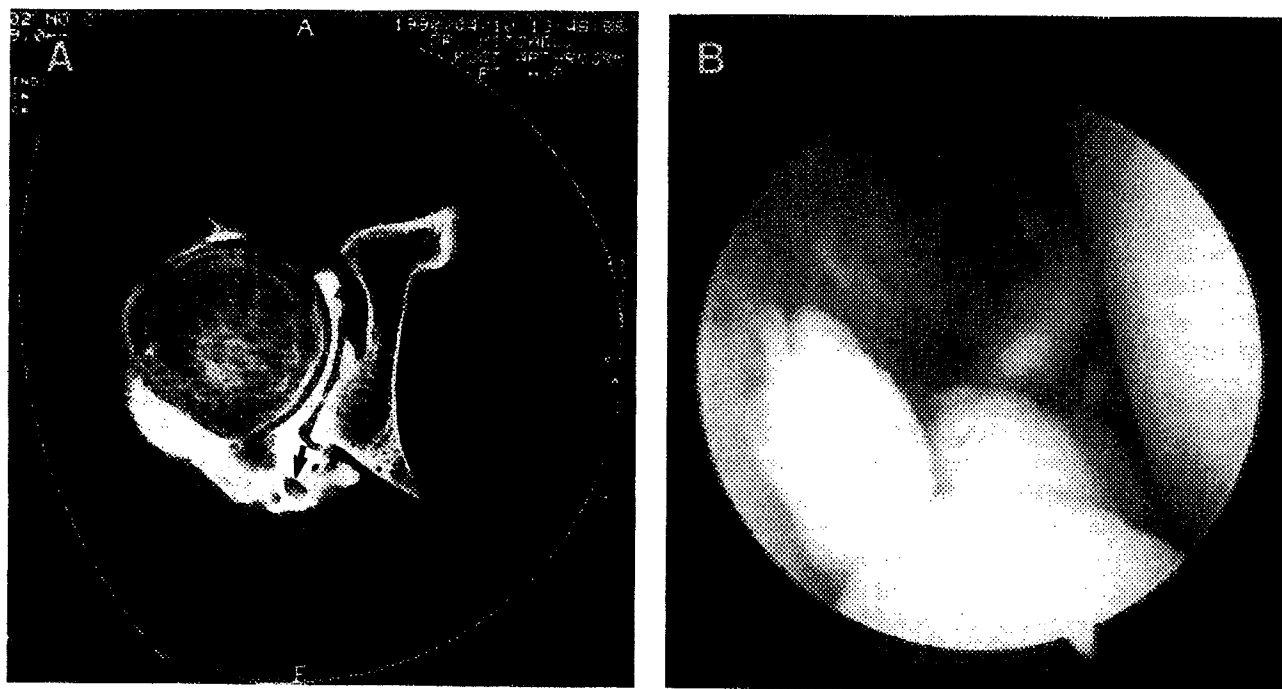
A 16-year-old boy with painful catching of the right hip 2 years after closed treatment of an acetabular fracture. (A) Double-contrast arthro-CT scan reveals multiple cartilaginous loose bodies, characterized by the filling defects seen posteriorly at the bottom of the picture (arrow). (B) Arthroscopic view of multiple loose bodies.
